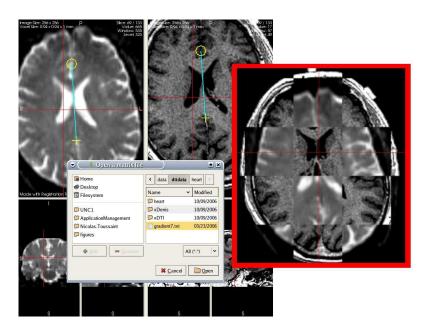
Screenshot of the future registration module showing a manual rigid registration of a DT-MRI baseline image (left) on a T1 image (right). The registration can be visually evaluated with a grid mixing the two images (red square on the right).
